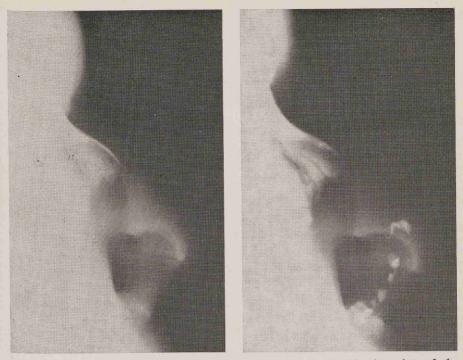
Same case. X-ray control immediatly after implantation of the cartilage (c) and 4 years later (d). The implant shows a good calcification which ensures an adequate projection of the nasal tip.
